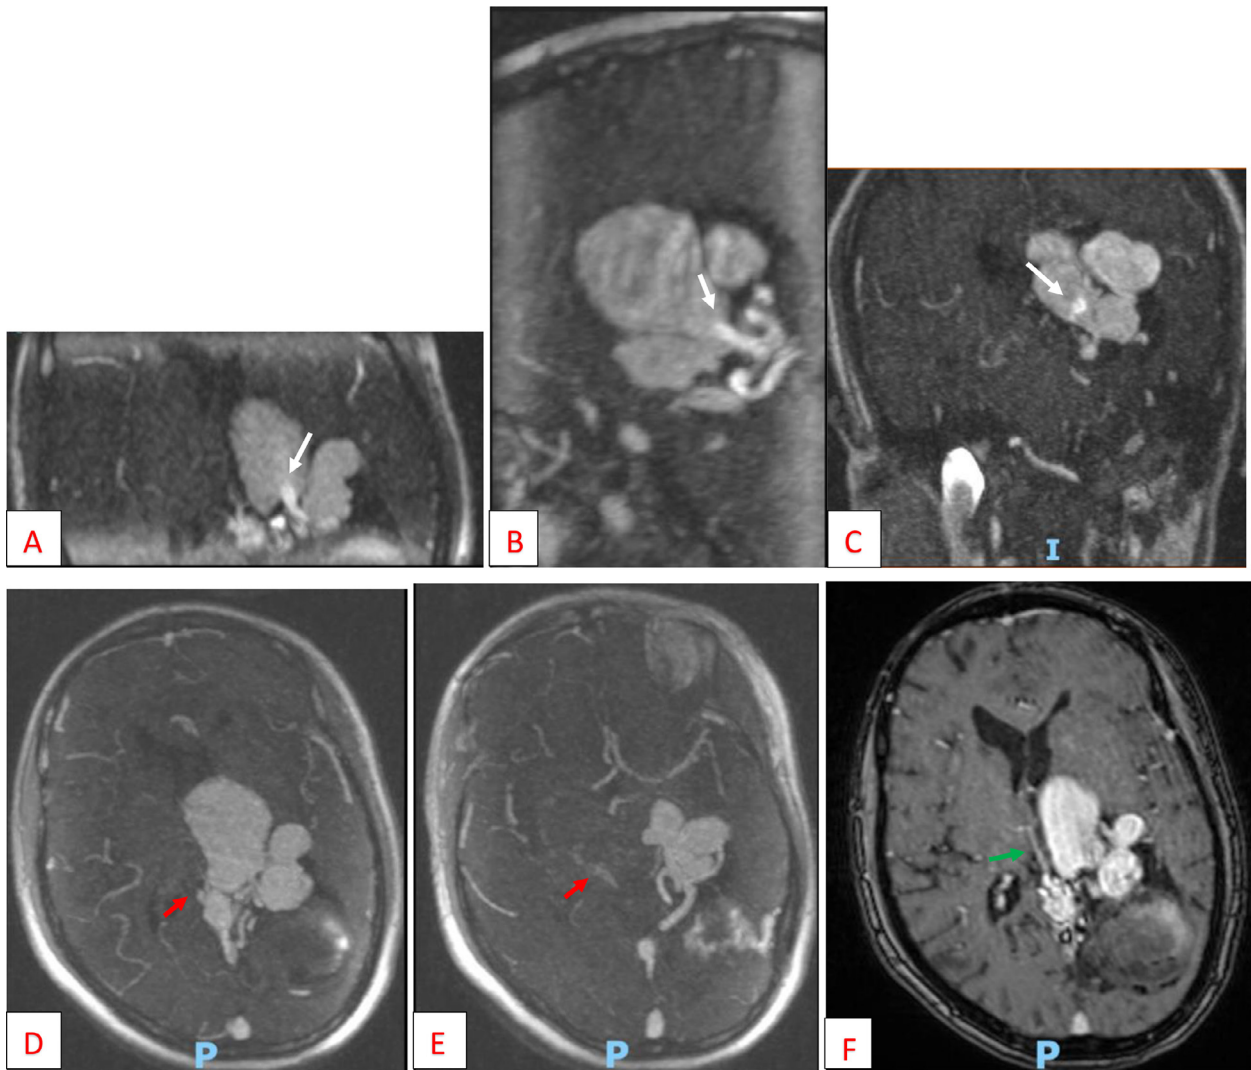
Contrast-enhanced magnetic resonance angiography (CE-MRA) findings. CE-MRA images in axial (A), sagittal (B) and coronal planes (C) demonstrate the shunt point (white arrow) by the abrupt change in caliber and signal intensity between the feeding arteries and the draining vein. Contrast-enhanced magnetic resonance venography (CE-MRV) images (D and E) and postcontrast T1-weighted axial image (F) show the connection of right superior thalamic vein (green arrow) and right basal vein of Rosenthal (red arrow) with the dilated vein of Galen.
